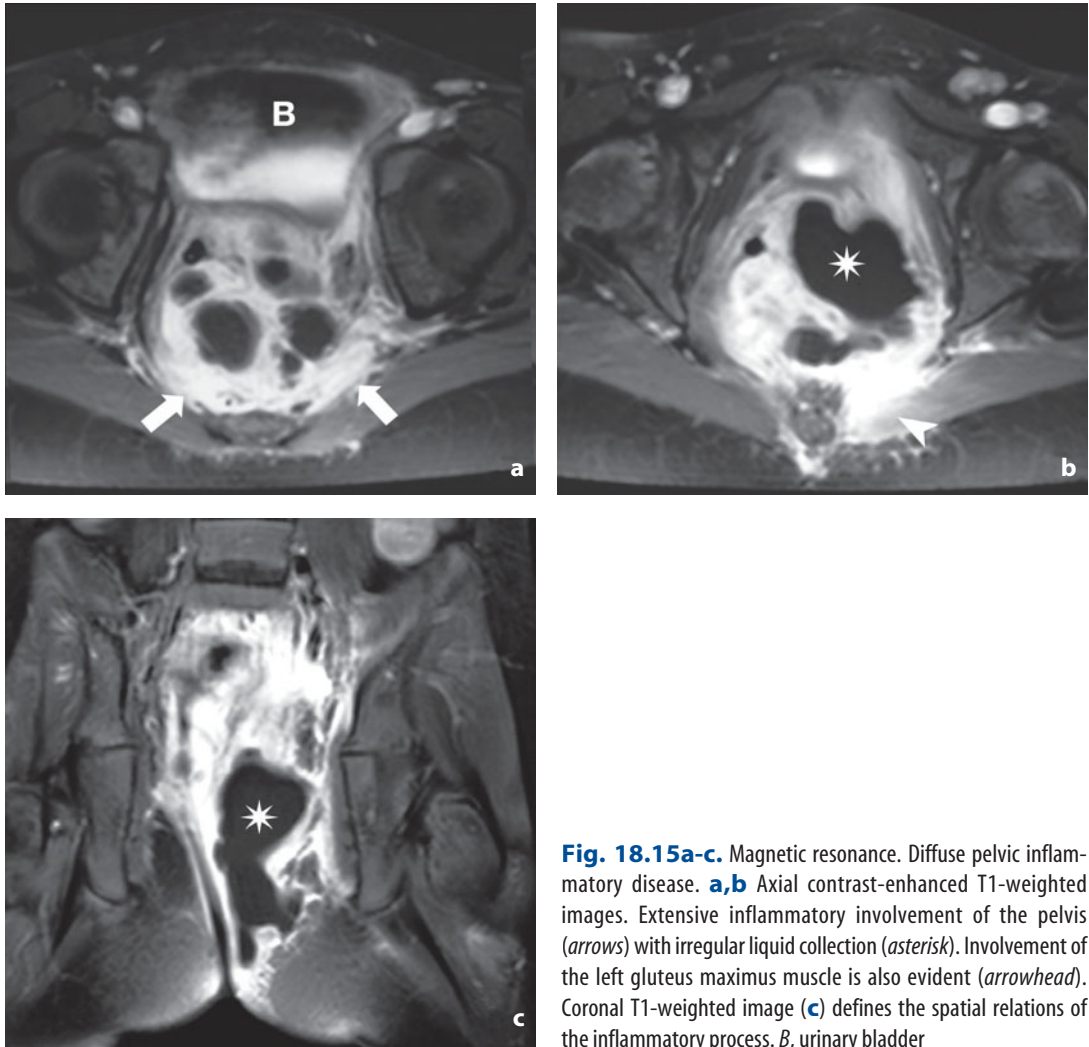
Magnetic resonance. Diffuse pelvic inflammatory disease. a,b Axial contrast-enhanced T1-weighted images. Extensive inflammatory involvement of the pelvis (*arrows*) with irregular liquid collection (*asterisk*). Involvement of the left gluteus maximus muscle is also evident (*arrowhead*). Coronal T1-weighted image (c) defines the spatial relations of the inflammatory process. *B*, urinary bladder
